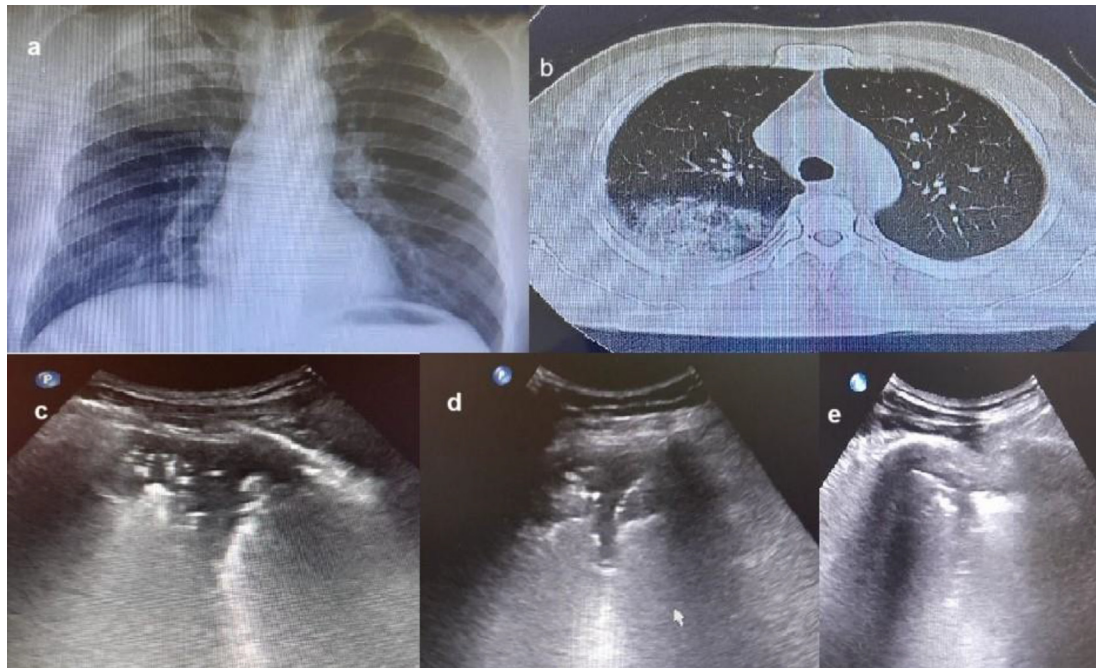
Figure shows the chest radiography (a) and, computed tomography (b) of right-sided consolidation, transthoracic ultrasound (c) shows the consolidation with air-bronchograms with pleural effusion and shred sign. Follow-up of transthoracic ultrasound on day 7 (d), and day 14 (e) shows gradual improvement of each finding.
